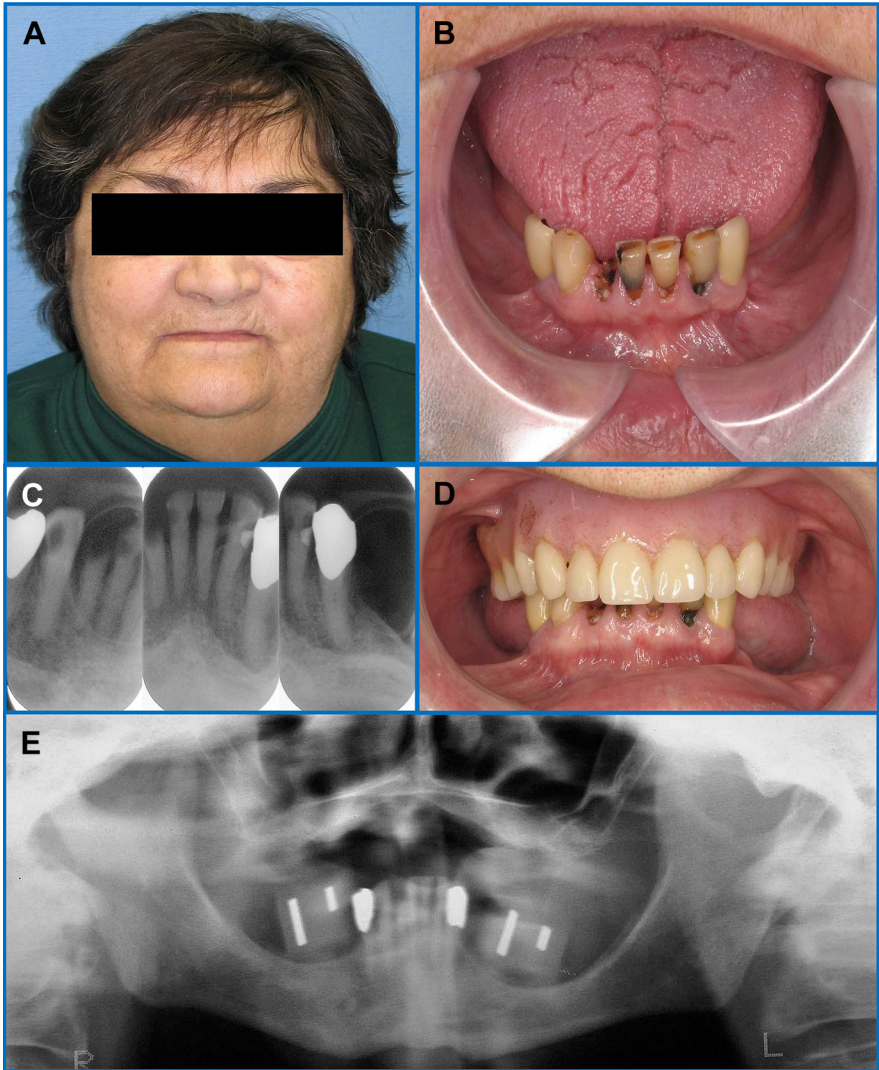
Pretreatment photos and radiographs. (A) Face showing lack of lip support. (B) Remaining teeth. (C) Periapical radiographs. (D) Preexisting maxillary complete denture. (E) Panoramic radiograph.
